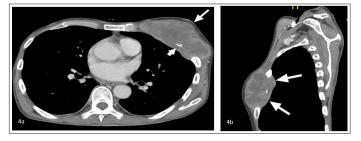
CT Scan Thorax (4a) Showing a Huge Mass with Necrotic Center Occupying the Whole Left Breast (White Arrow) with Infiltration to the Chest Wall, Erosion of the Adjacent Ribs (Short Arrow) and Extension of the Lesion (4b) into the Thoracic Cavity
